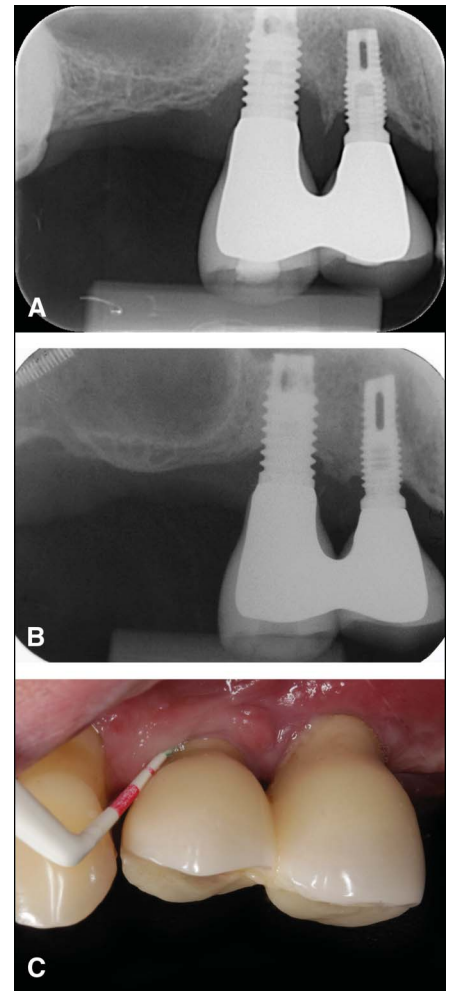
Periimplantitis affecting the implant at position 14. A, Preoperative periapical x-ray showing bone loss around the implant; B, periapical x-ray after 13 months of treatment showing bone formation around the proximal sites of the implant; C, clinical situation at the 13-month follow-up showing healthy periimplant tissues with no signs of inflammation.
